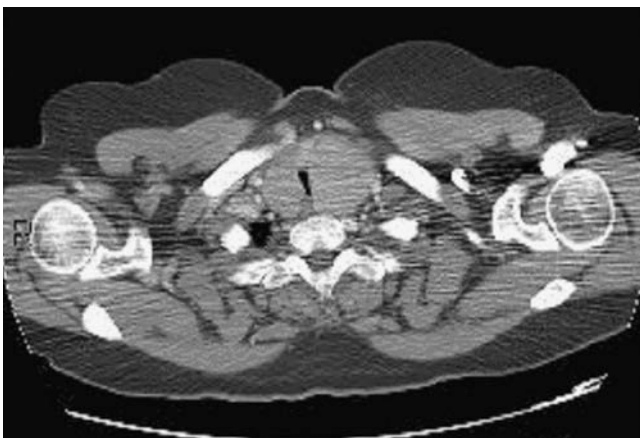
Computed tomography scan (with intravenous contrast) of lower neck–upper thorax region reveals an enlarged thyroid gland (goiter) compressing the trachea and esophagus. Anesthetists must recognize the potential for significant airway compromise during induction of anesthesia in patients with large goiters in the neck and anticipate possible extension of the goiter to the retrosternal space. Up to 6% of tracheal intubations in patients anesthetized for thyroid surgery are difficult.
